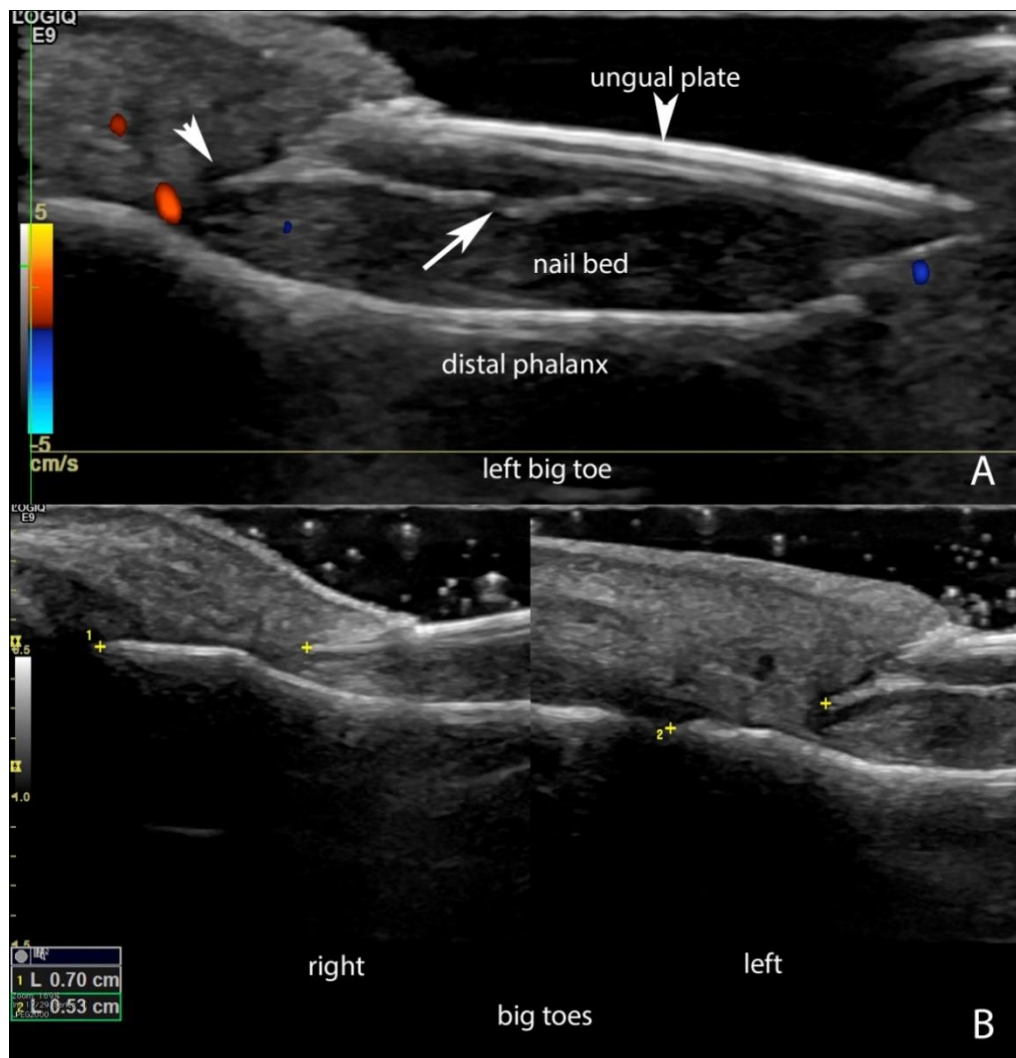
(A,B). Color Doppler ultrasound of retronychia and partial onychomadesis of the ventral plate at the left big toe (A, longitudinal view left big toe; B, side-by-side comparison of the big toes; longitudinal views). A. Diffuse thickening and decreased echogenicity of the ungueal bed that involves the matrix region with hypoechoic halo surrounding the origin of the nail plate (oblique arrowhead pointing down). Notice the fragmentation of the ventral plate (long arrow pointing up) and the prominent periungueal vessels (in colors). B. Decreased distance between the origin of the nail plate and the base of the distal phalanx at the left big toe (5.3 mm left versus 7.0 mm right). Notice the thickening of the dermal layer of the proximal nail fold at the left side
